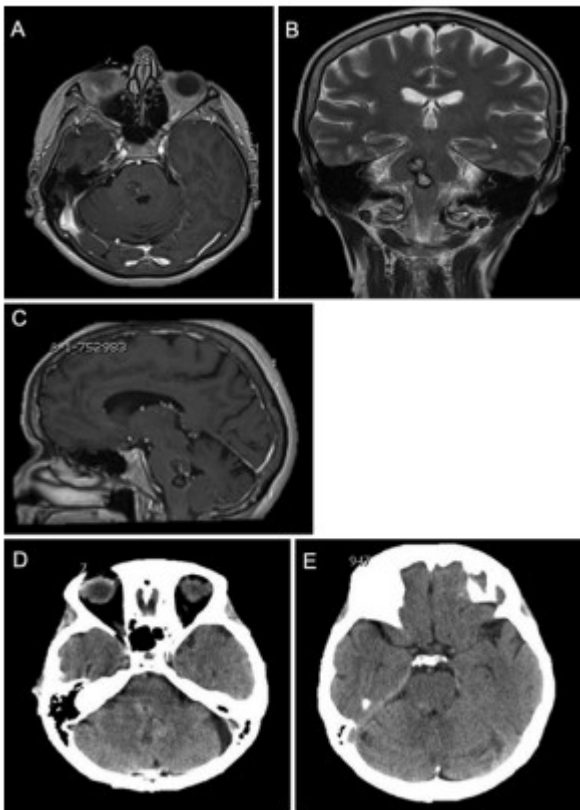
Case 4. Preoperative MRI showing a cavernoma at the pontomedullary junction in axial Gd-enhanced T1-weighted (A), coronal T2-weighted (B), and sagittal Gd-enhanced T1-weighted (C) sections. Postoperative CT scan showing in more caudal (D) and more cranial (E) sections the surgical entry point at the level of the floor of the fourth ventricle, reached through the midline suboccipital telovelar approach.
